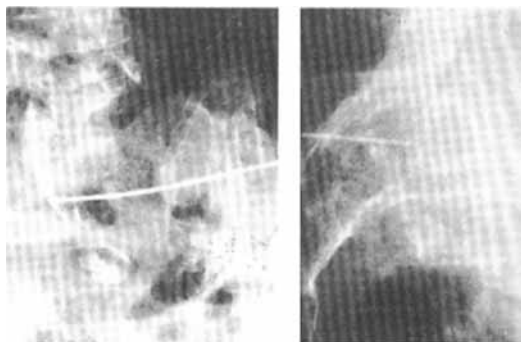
A-P and lateral radiographs of an S1 nerve root sheath infiltration. Note the location of the needle tip.
